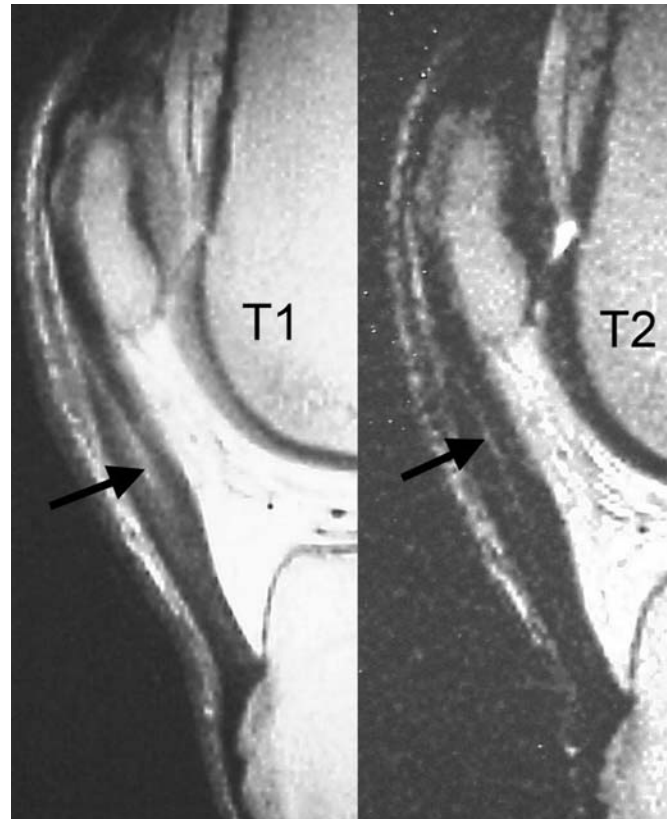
Sagittal plane T1 (left) and T2 (right) MRI of the patella tendon. High signal in the proximal tendon represents myxoid change of chronic tendinopathy (arrows).
